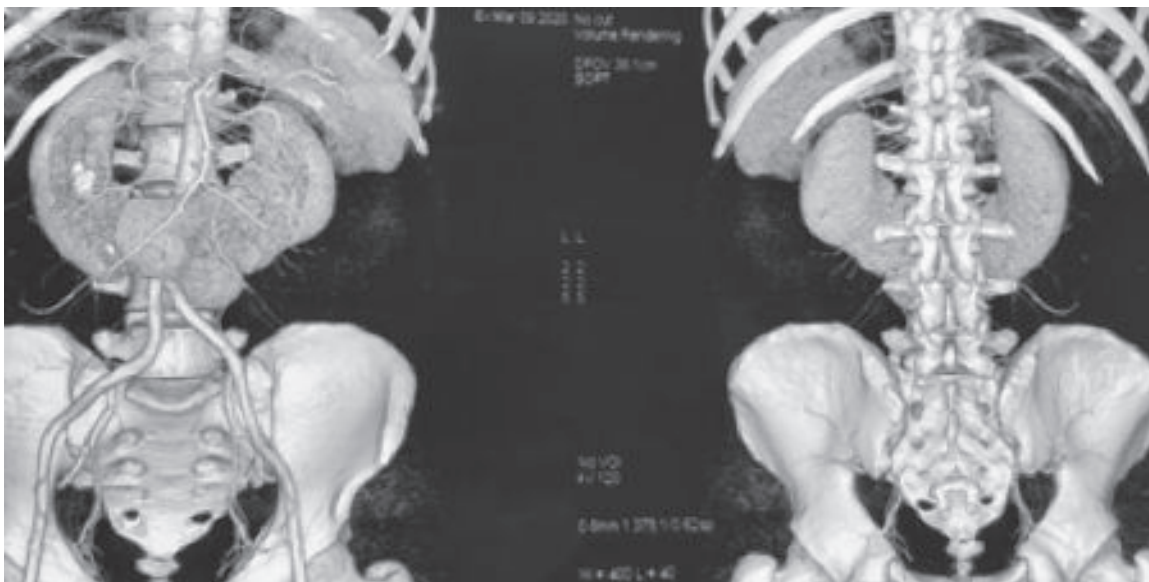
CT Urogram Shows Horseshoe Kidney with Rt Renal Stone
